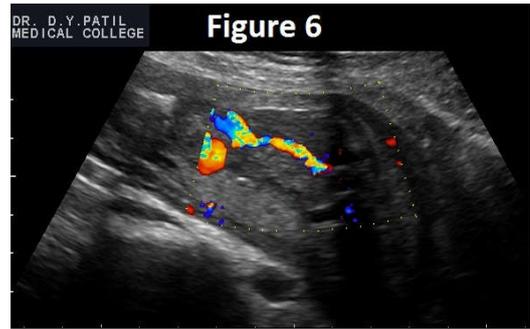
Color Doppler showing single umbilical artery.
